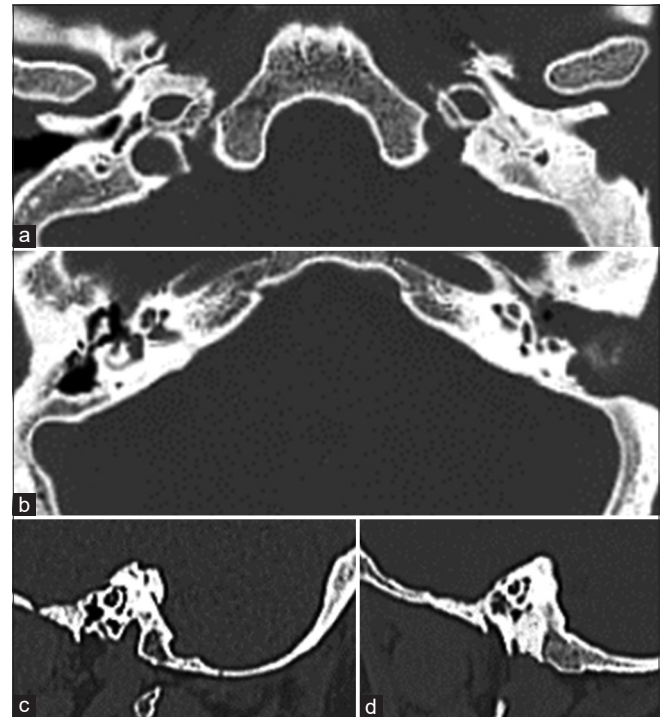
Left absent jugular bulb (JB). Case 4: High-resolution computed tomography B/L temporal bone of 43-year-old male. (a) Axial section: Left-sided JB not visualized, right-sided normal JB (b) Axial section at the level of the cochlea: B/L JB not visualized (c) Sagittal section through right cochlea: Right JB at normal position (d) Sagittal section through left cochlea: Left JB not visualized
